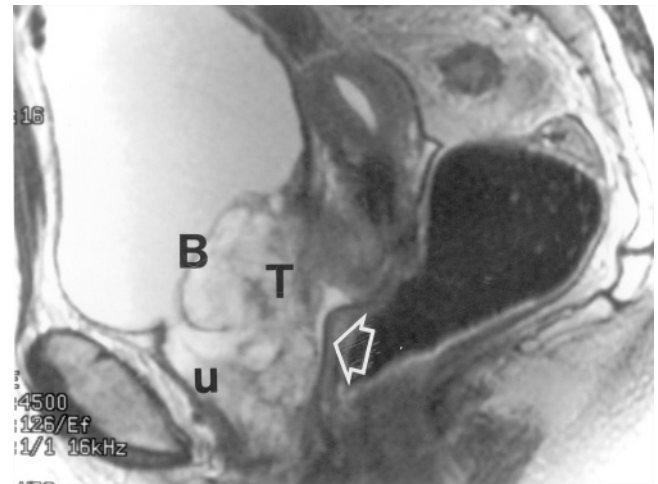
Invasive clear cell adenocarcinoma of the vagina. Sagittal T2-weighted ETSE image in a 68-year-old woman unrelated to DES exposure shows a large heterogeneous intermediate- to high-signal-intensity mass (T) in the anterior wall of the proximal vagina with gross invasion of the posterior bladder wall (B) and the posterior urethra (u). The posterior vaginal wall is preserved (open arrow).
